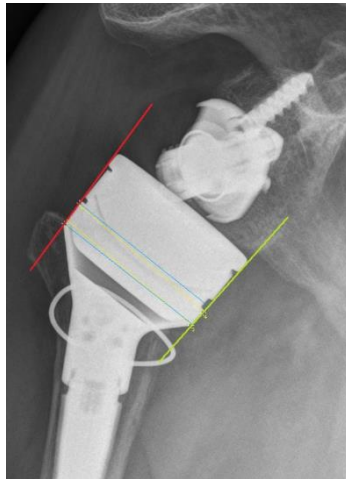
Estimation of reverse humeral body dimension from standard AP shoulder radiograph. The lateral edge (highlighted in red) and the medial edge (highlighted in yellow) of the component were defined. The transverse size of the humeral body was determined as the mean perpendicular distance between the edges [I].
